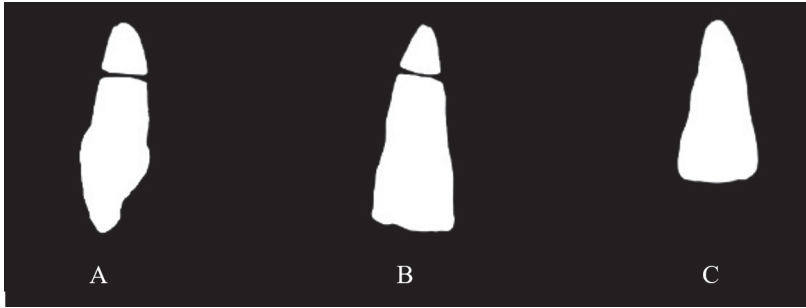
The different radiographic appearances of a horizontal root fracture.
